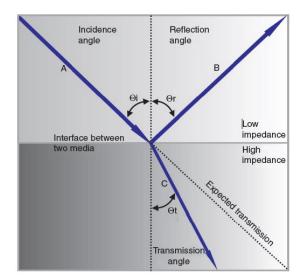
The interaction of ultrasound waves through the media in which they travel is complex. When ultrasound encounters boundaries between different media, part of the ultrasound is reflected, and part transmitted. The reflected and transmitted directions depend on the respective angles of reflection and transmission.
